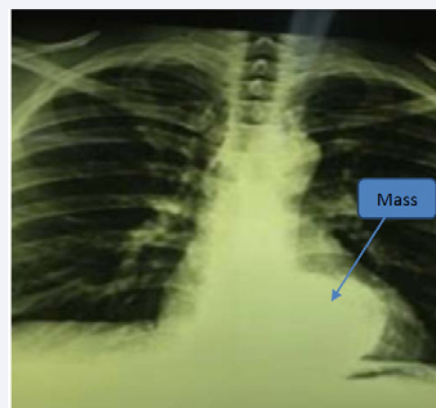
Chest X-Ray (PA) shows an about 8×6 cm mass in the left lower-chest area over the heart shadow.
